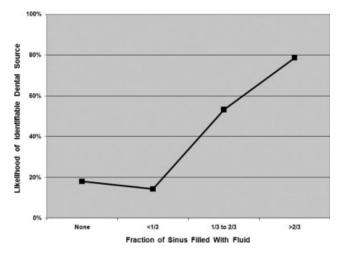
Association between maxillary sinus fluid and dental source of infection. The likelihood of identifying a dental source of infection radiographically increased with the amount of fluid in the sinus. Patients with <1/3 of the sinus filled with fluid were unlikely to demonstrate a dental source.
